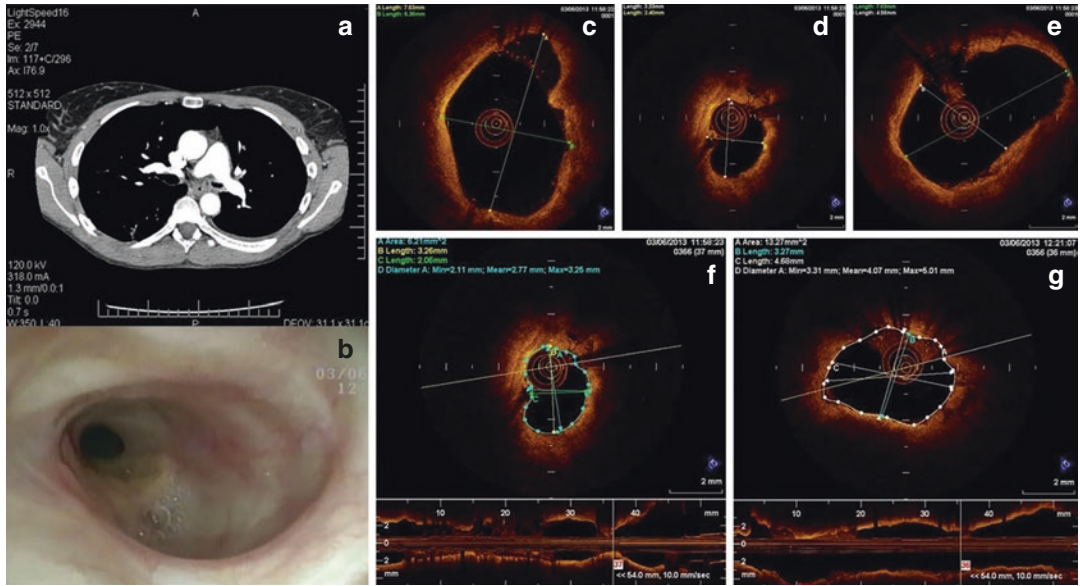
Application of OCT image for measurement of tracheobronchial stenosis. CT scan (a) and bronchoscopic (b) image of left main bronchus stenosis. OCT images of normal bronchial lumen before (c) and after (e) of the bronchial stenosis (d). OCT allows accurate measurements pre (f) and post (g) treatment with balloon dilatation. (Courtesy from Dr. Shaipanich and Dr. Lam)
